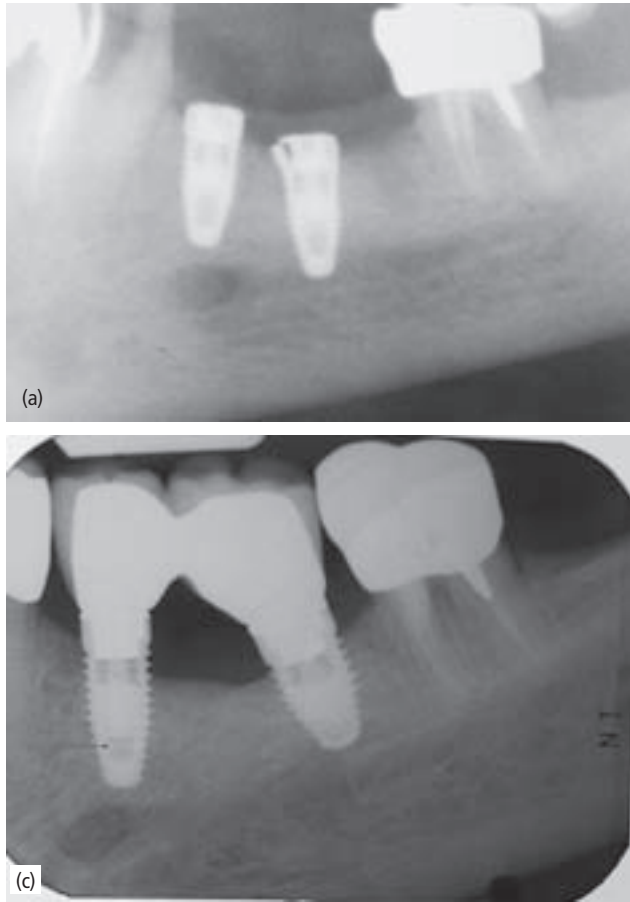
(a) Radiograph showing fractured internal connection and fraying of the implant interface that occurred during implant placement in type I bone. (b) Retrieved implant and defect along the implant platform. (c) Radiograph taken 2 years after completion of a splinted restoration on the replaced implant. (Courtesy of Stuart Froum.)
